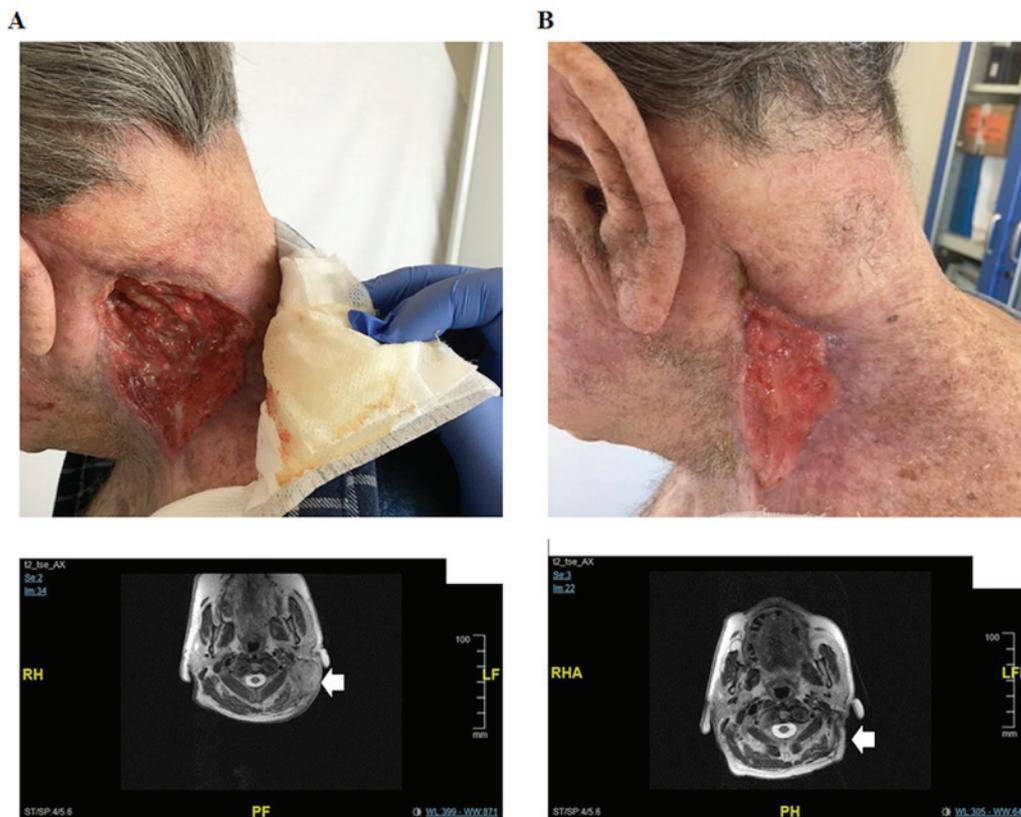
Lesion and MRI of the patient before and after cetuximab-curcumin treatment for recurrent cSCC of the supraclavicular region. Tumor masse (arrow) can be seen in the nuchal and supraclavicular regions of the patient before initiation of cetuximab-curcumin treatment. Moreover, the supraclavicular 10 cm lesion appeared ulcerated at the medical examination (A). The masse (arrow) became significantly reduced in size on MRI obtained 12 weeks after treatment (B), indicating good response to combination treatment.
